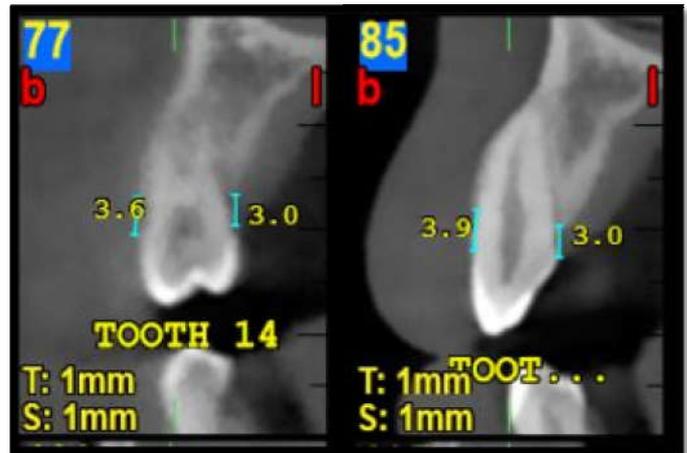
Post OP 6 Months CBCT IBD measurements
